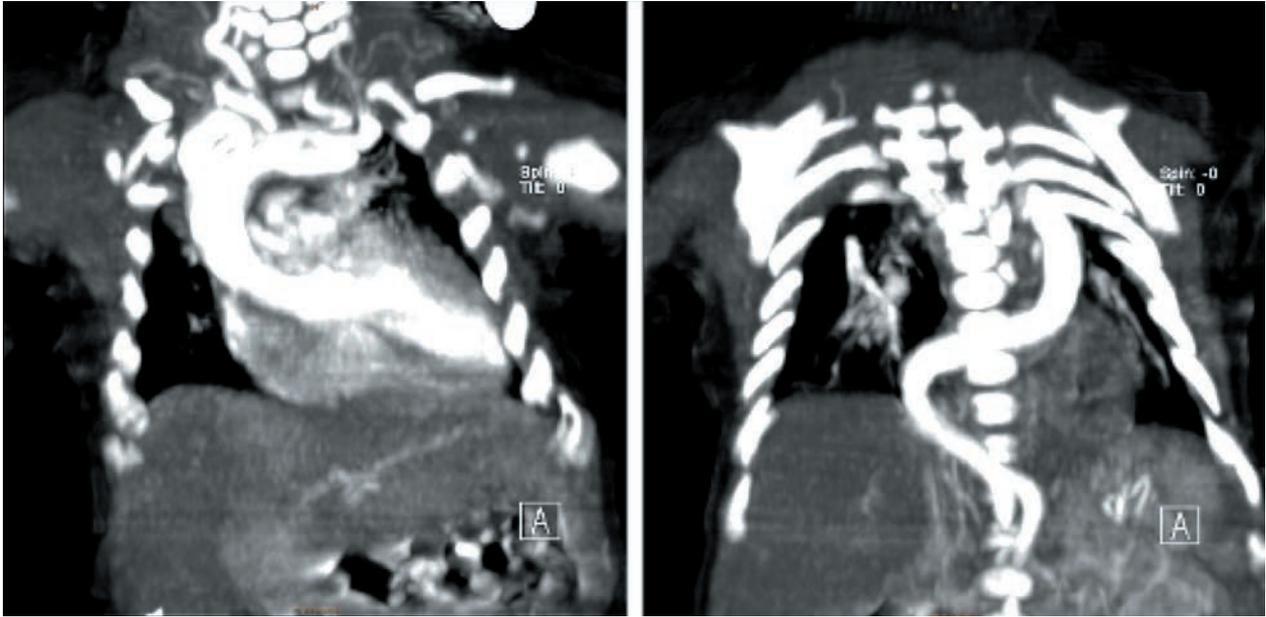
Thoracic CT-scan coronal cuts at 13 days of age. Redundant aorta.
